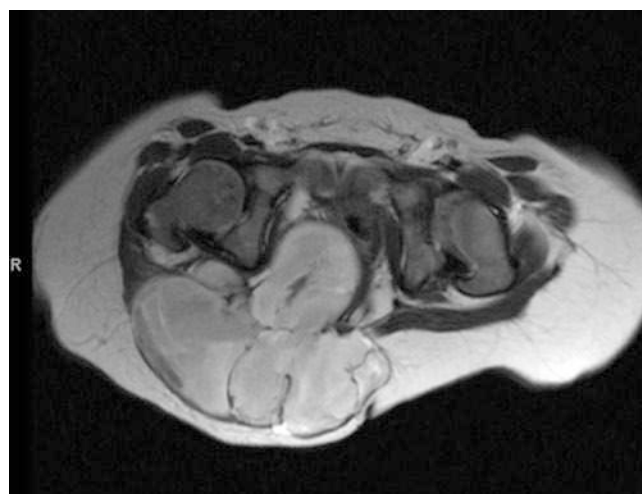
Infantile fibrosarcoma in a 2-week old girl with a buttock mass. Axial T2-weighted image shows a heterogeneous soft tissue mass extending from the ischiorectal fossa into the gluteal region
